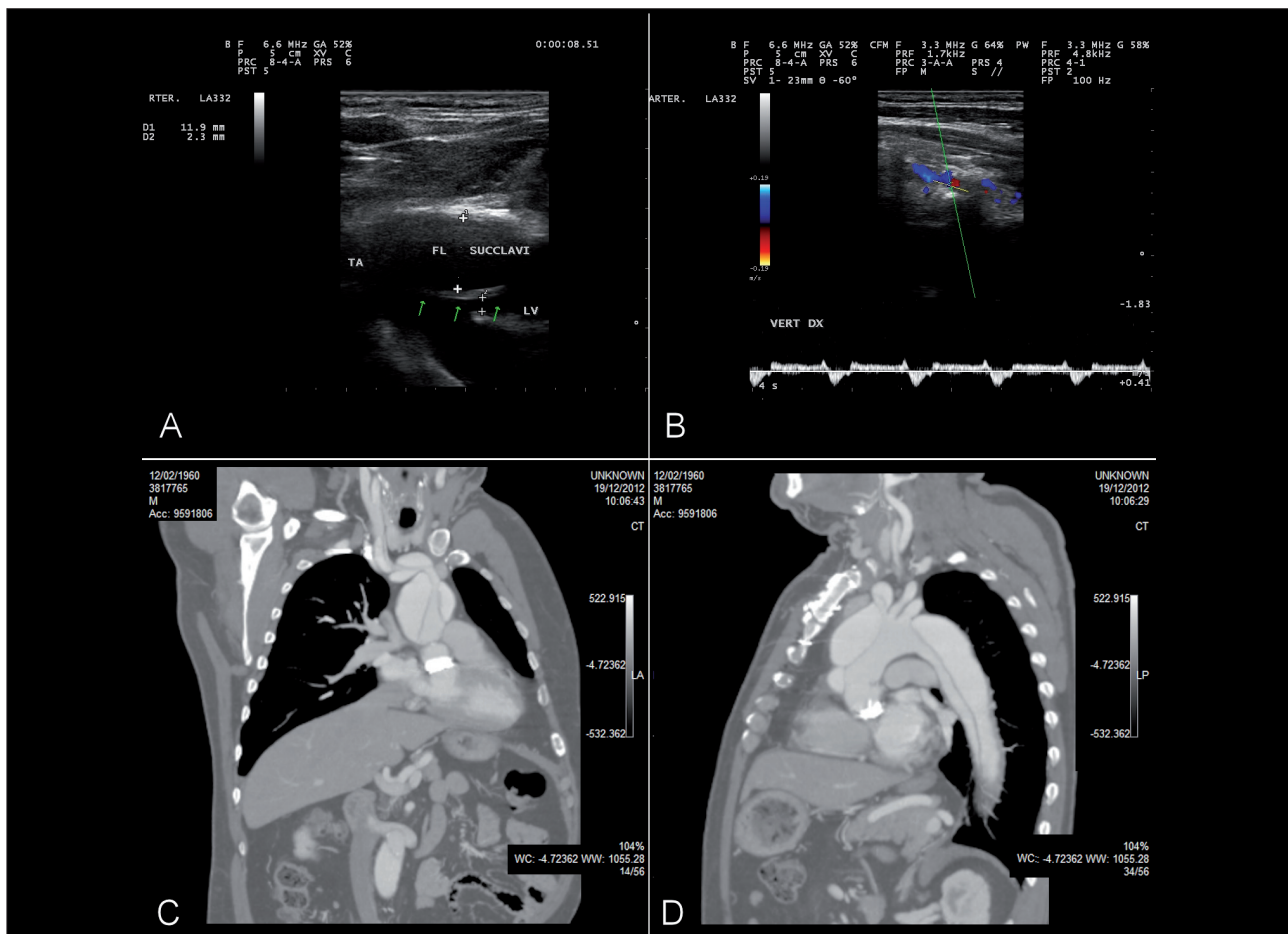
A: Ultrasound imaging of the right subclavian artery showing the dissection. FL: False lumen. LV: True lumen. Arrows: intimal flap. B: Doppler flow in the right vertebral artery showing an intermittent flow. C: CT imaging, oblique view focused to present the extent of the dissection to the supra-aortic vessels. D: TC Imaging, lateral view: the dissection extends towards the descending aorta.
